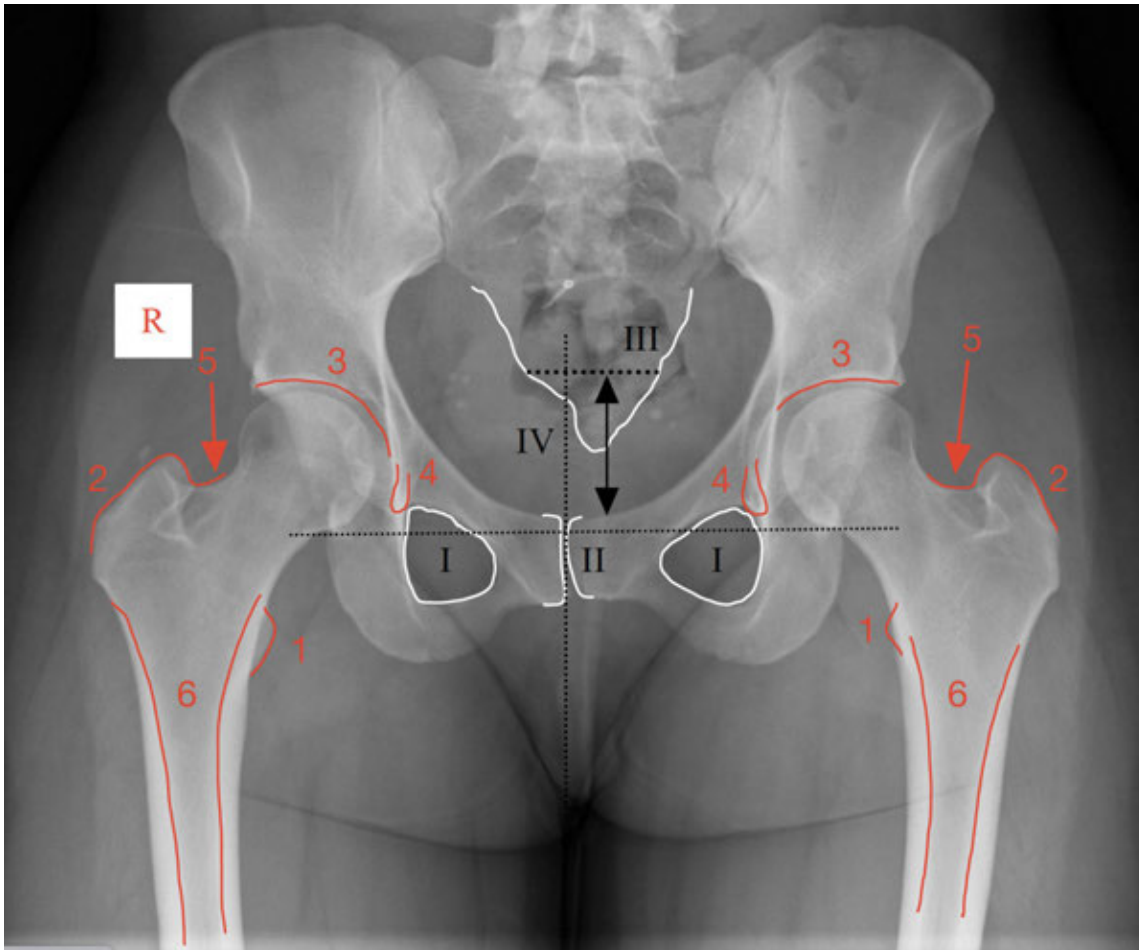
Standing anterior posterior pelvic radiograph for templating the hip. (A) Anatomical landmarks: 1. Lesser trochanter; 2. Greater trochanter; 3. Acetabular roof; 4. "Teardrop"; 5. "Saddle"; 6. Femoral shaft. (B) Landmarks for assessing radiographic quality: I. Obturator foramen; II. Pubic symphysis; III. Sacrum; IV. Distance between pubic symphysis and sacrococcygeal joint.
